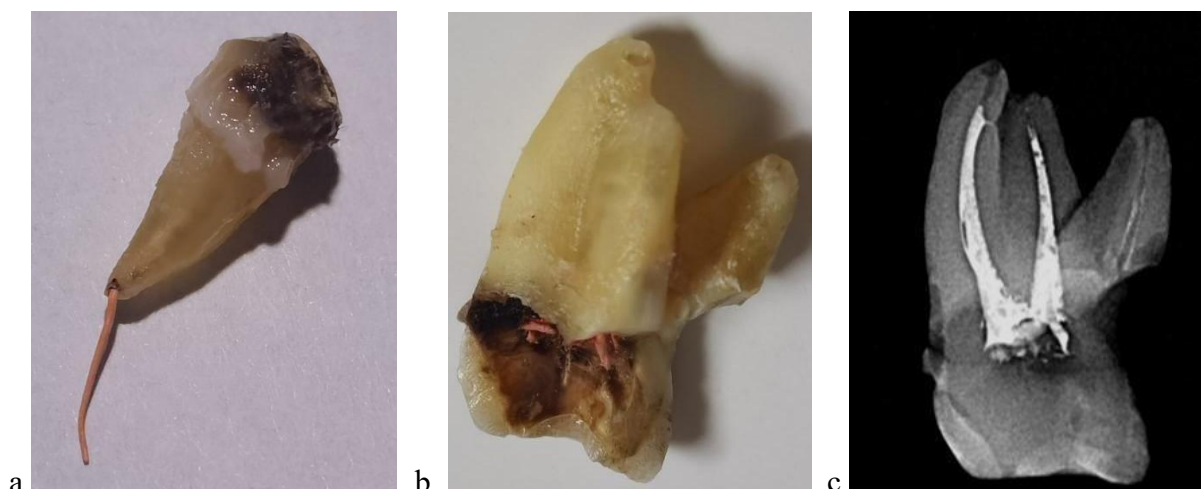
Photo of tooth 35, extracted 2 years after treatment. Gutta-percha pin removed through the destroyed apical constriction (a). Horizontal and vertical root resorption of tooth 17 2 years after filling. Thinning of the buccal root wall along the entire length, shortening of the roots along the length, wide apical foramina (b). Radiograph of tooth 17 (c).
